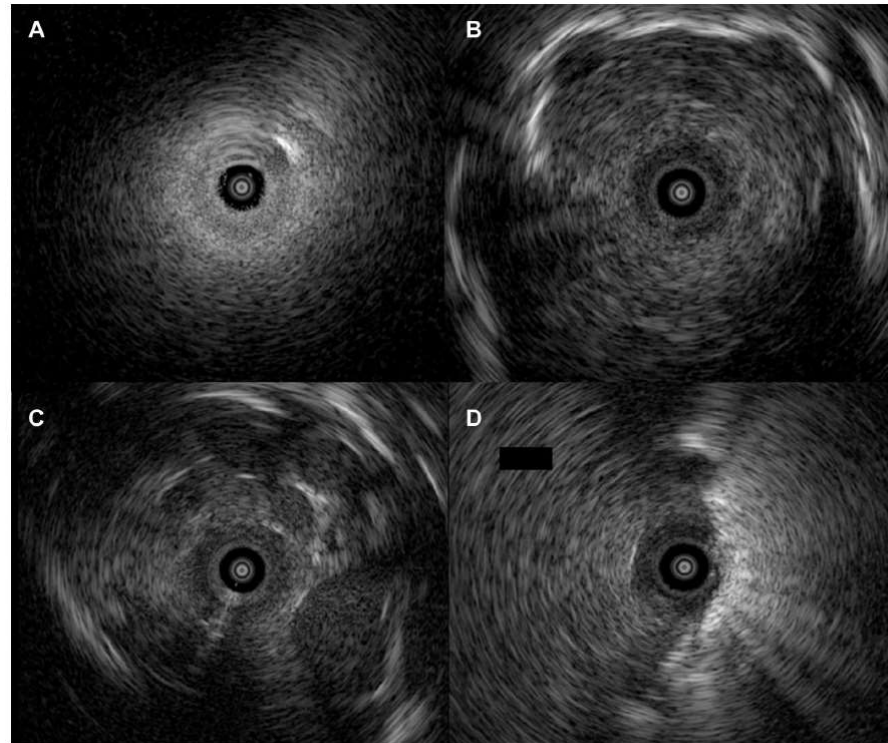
Radial-probe endobronchial ultrasound patterns. A, Aerated lung (snowstorm). B-D, Various patterns of nonaerated lung or atelectasis: concentric “tumor-like” with clear borders (B); concentric irregular with poorly demarcated borders (C); eccentric (D). (All images taken with 4-cm depth scanning).
